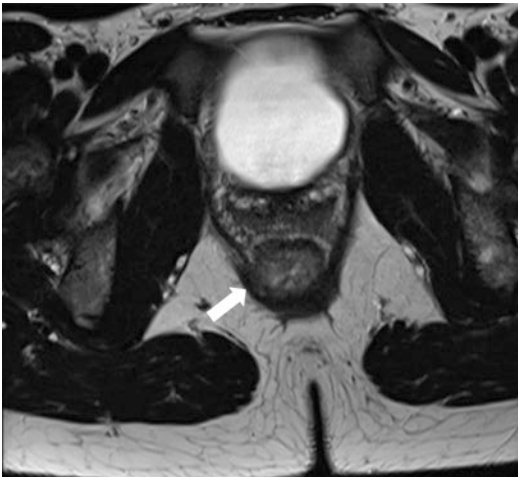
Axial MRI of low rectal cancer invading the intersphincteric plane
